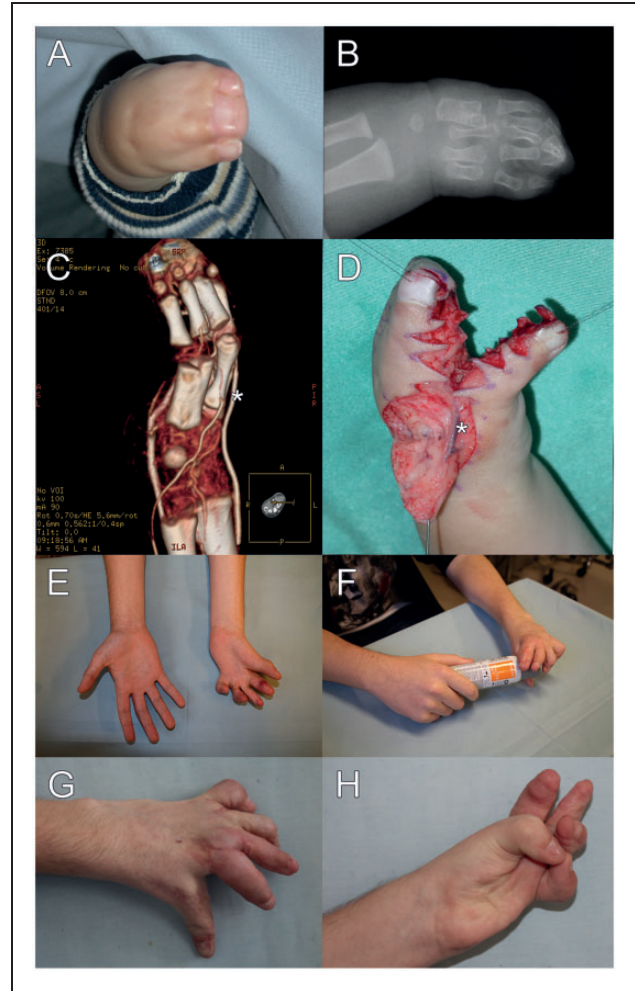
(a) This 15-month-old boy had a rare non-syndromal Apert-like malformation of the left hand, Upton Type III, without associated malformation of the feet or skull. (b) X-ray examination hinted at bony fusion of the distal phalanges of the central rays and partial osseous syndactyly of the fourth and fifth metacarpal bones. (c) MDCT showed that the main vessel supplying the hand was a strong ulnar artery, dividing into two main branches at the level of the third metacarpal head after supplying the fifth digit. The hypoplastic radial artery divided to a small superficial palmar arch and a princeps pollicis artery, travelling to the dorsum of the hand (asterisk). (d) This knowledge was useful for planning a well-supplied local rotation advancement flap to line the first webspace (asterisk) correcting syndactyly with interdigitated ulnar- and radial-based mirror image Z flaps. At the age of 12 years (e and f) and 15 years (g and h), the result is aesthetically pleasing and functional.
